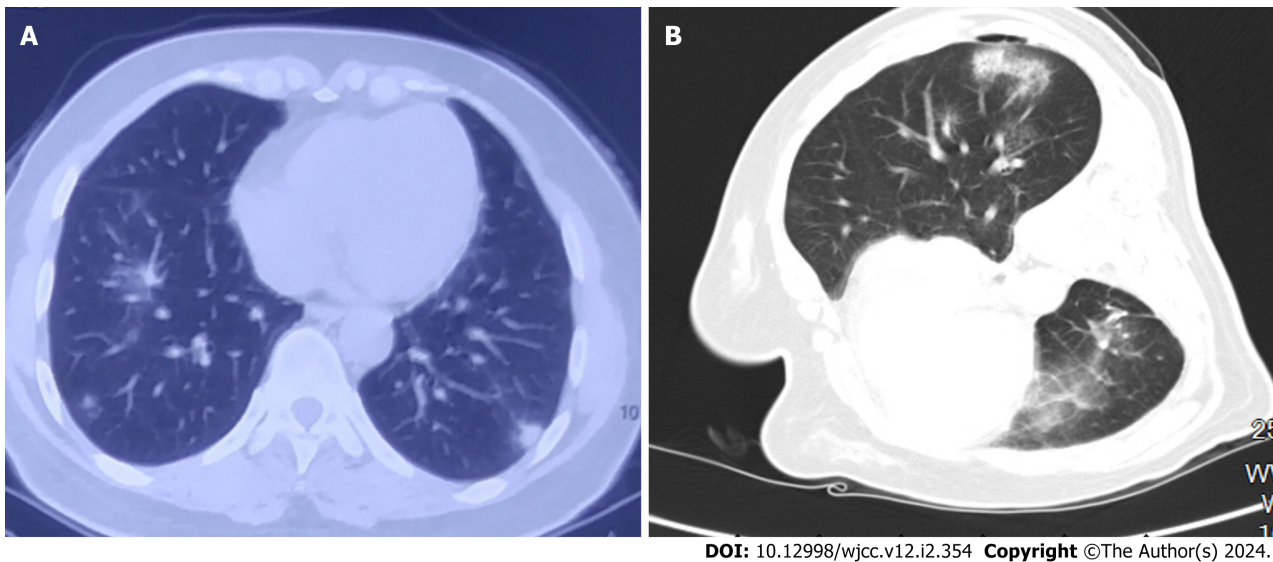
Lung imaging before and after lobectomy. A: Chest computed tomography (CT) showed two high-density pulmonary nodules in the posterior basal segment of the left lower lobe; B: Chest CT revealed a new pulmonary nodule in the right lower lobe (left lateral position).
